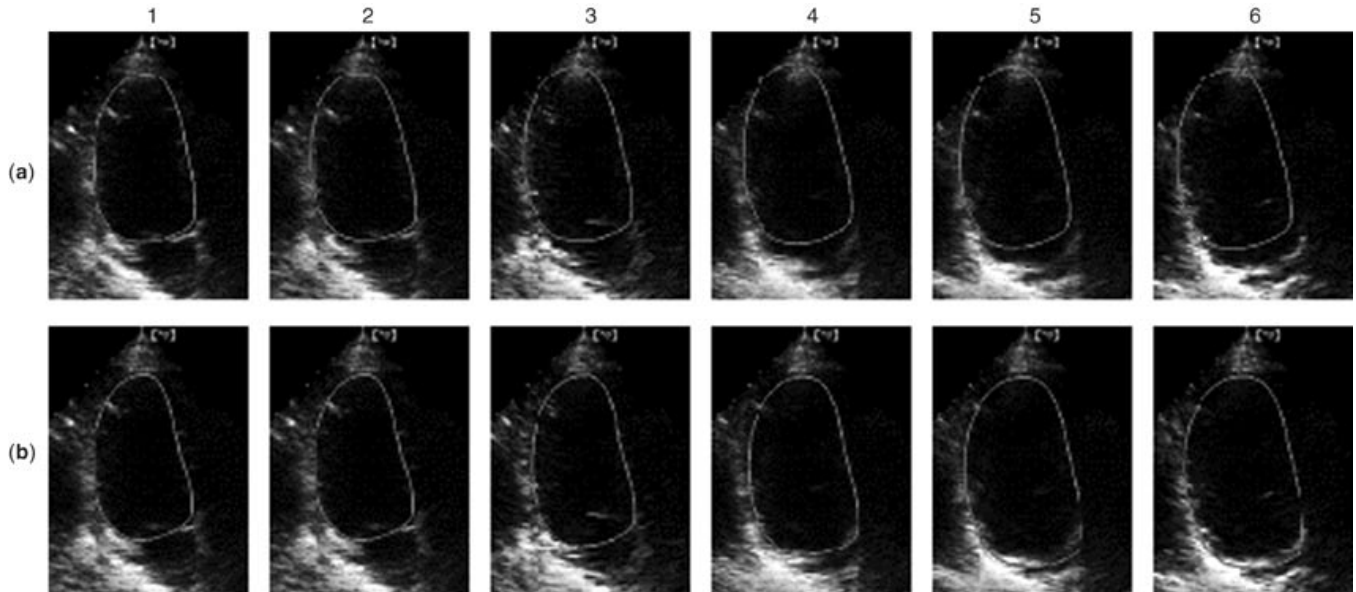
2-D echocardiogram model-based tracking: (a) tracking using a simple (affine) motion model; (b) tracking using a motion model learnt from some training data. The latter enables the actual motion to be followed more accurately; this is most clearly seen by comparing frames 4 to 6 in (a) and (b) (75).
